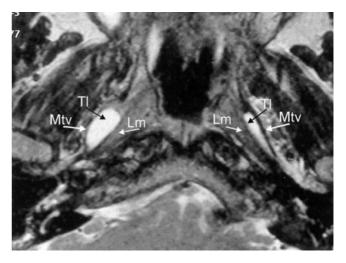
Transverse MR image at the level of the nasopharynx, turbo spin-echo sequence. The tubal lumen (TI) is fluid-filled due to a chronic inflammatory mucosal reaction with adhesion of the mucosal layers. Mtv = tensor veli palatini muscle, Lm = medial lamina of tubal cartilage. Female 52 years of age.
